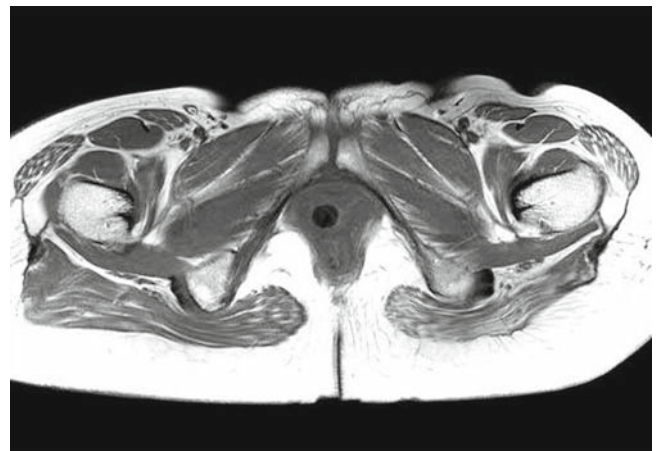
T1-weighted axial magnetic resonance imaging shows extensive fibrosis and atrophy of the left gluteus maximus muscle
